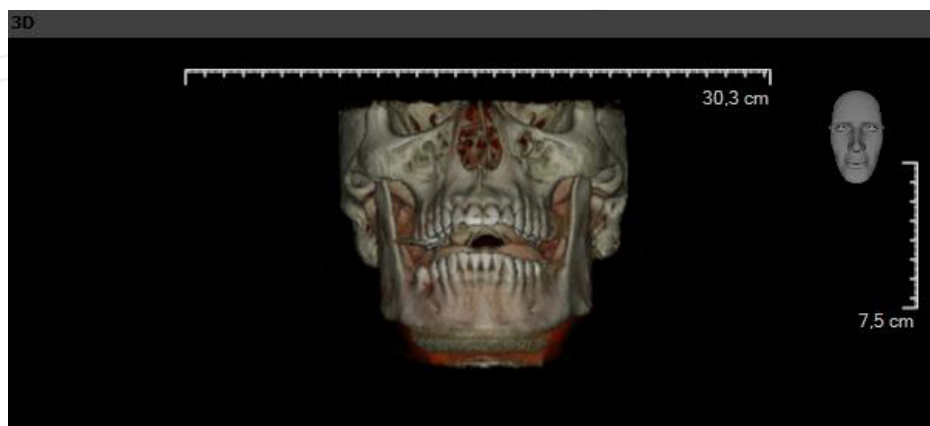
An example of a three dimensional CBCT image
